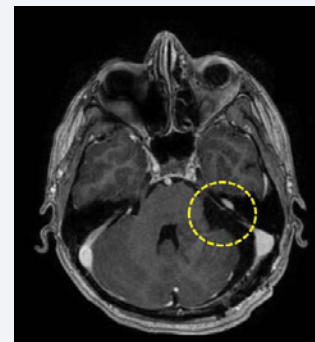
Postoperative T1 MRI without arteriovenous malformation (yellow circle).
